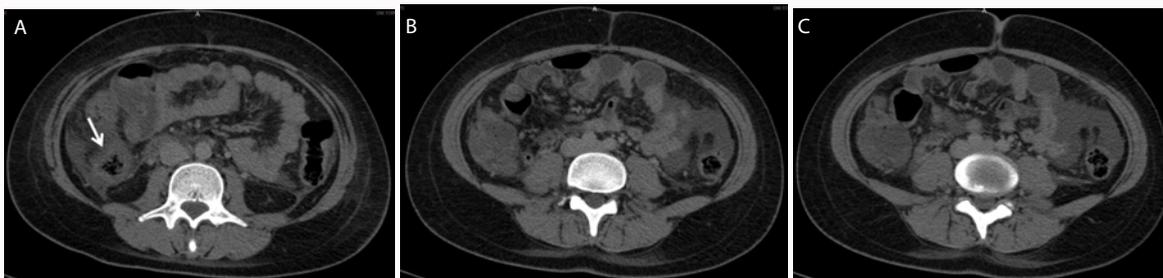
Contrast-enhanced CT scans show acquired at the level of the cecum had shown evidence of fat stranding in the retrocecal area, wall-thickening in the cecum and ascending colon (arrow).
